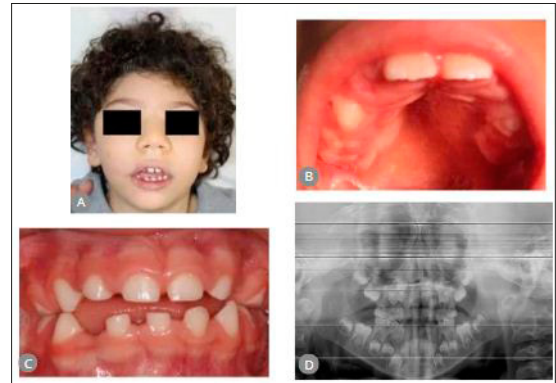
(A,B,C,D). Intraoral photographs and panoramic radiography of a patient with severe microcephaly, male, 6 years and 11 months of age, with primary dentition. In the mixed dentition, generalized gingival enlargement on the occlusal surfaces of the un-erupted upper permanent first molar can be seen
